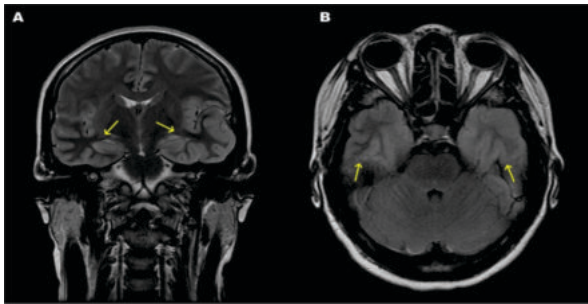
The T2-weighted magnetic resonance imaging (MRI) in coronal (A) and axial (B) planes, revealing hyperintensity (corresponding to edematous changes) in the bilateral temporal lobes.
